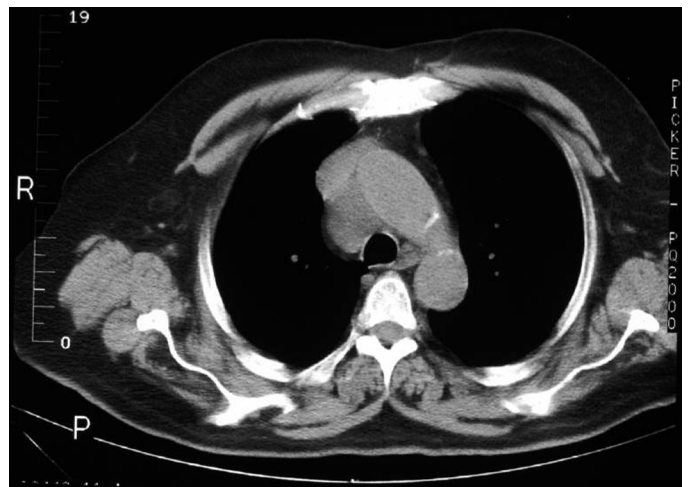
Preoperative computed tomographic scan shows right paratracheal mediastinal cyst in patient 1.
